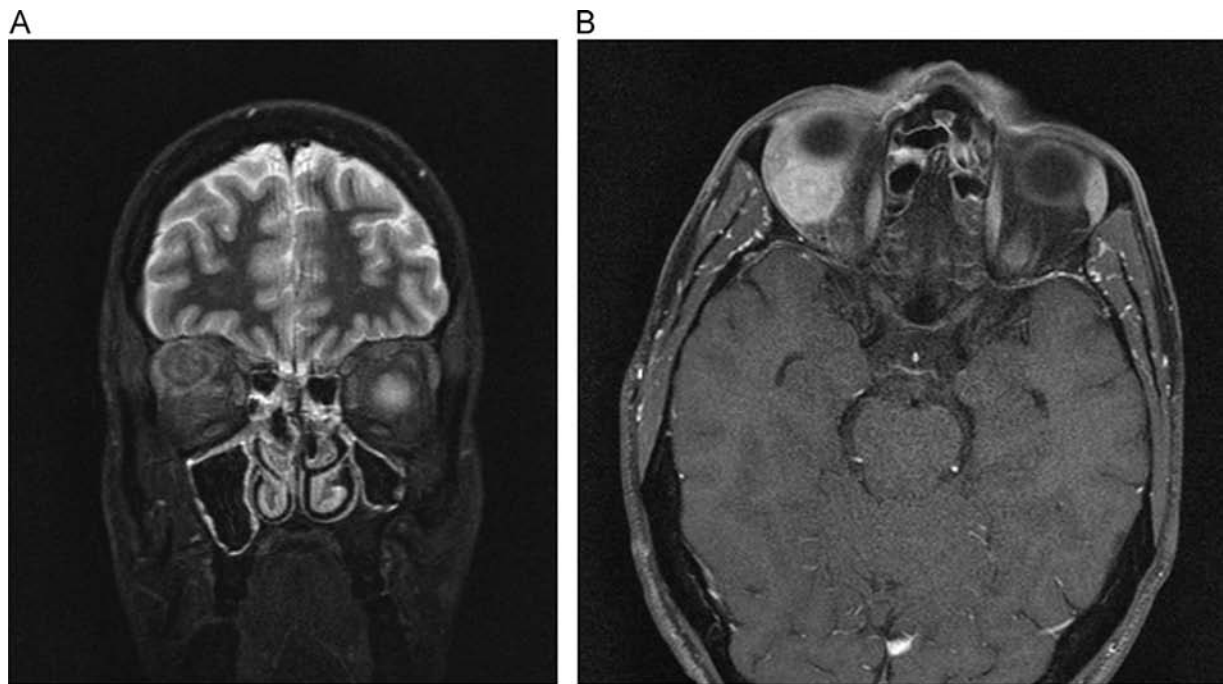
Coronal (a) and axial (b) magnetic resonance imaging images showing a well-defined mass in the superoposterior region of the right orbit.
